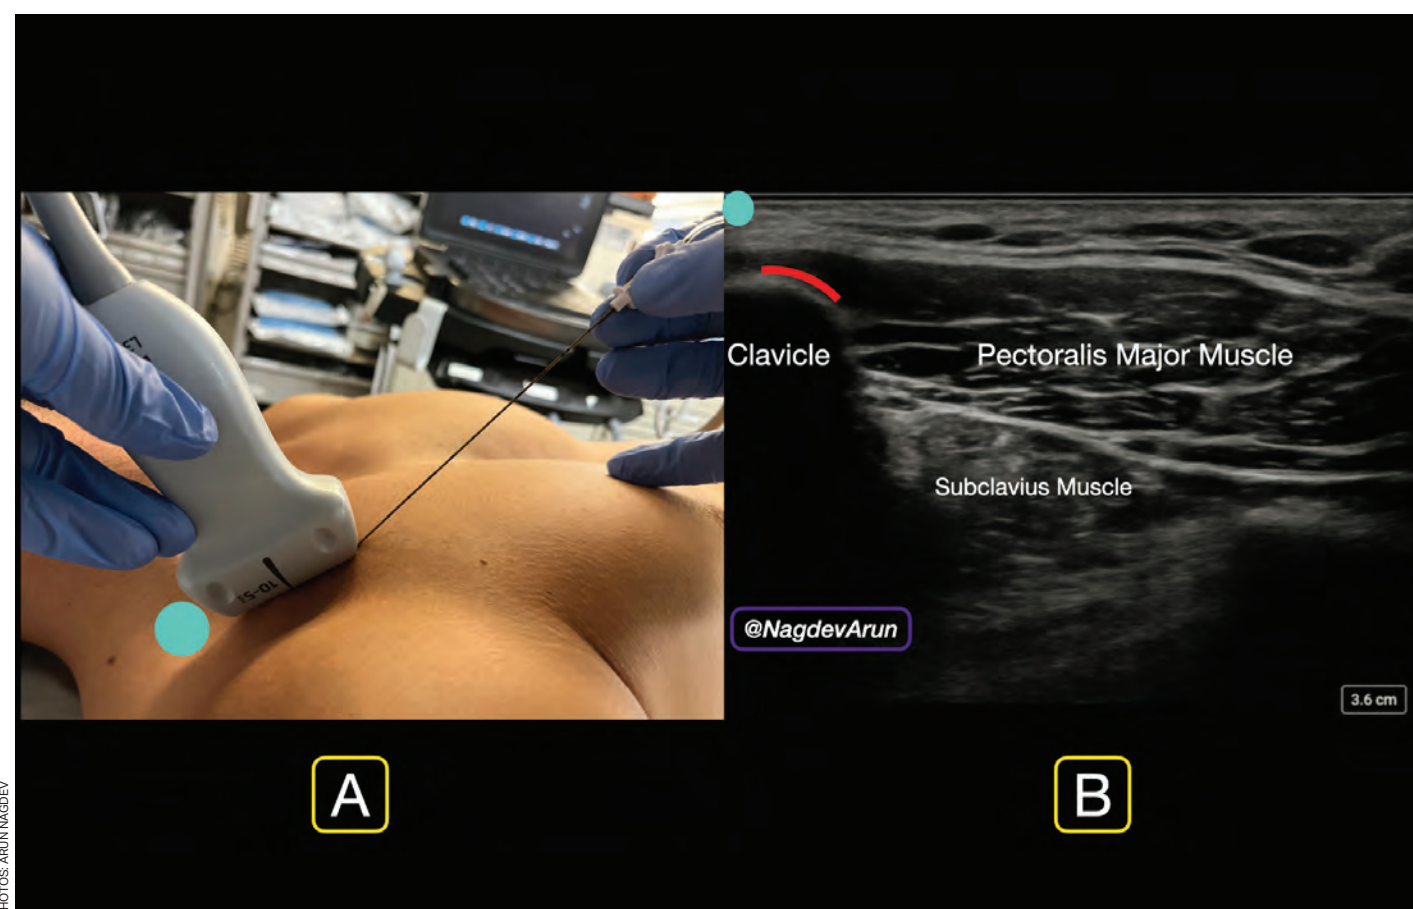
Ultrasound probe placed in a sagittal plane with the probe marker cephalad, in-plane needle technique.
